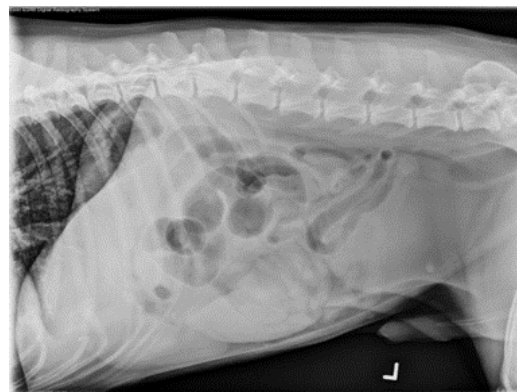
Right Lateral abdominal radiograph showing splenomegaly
